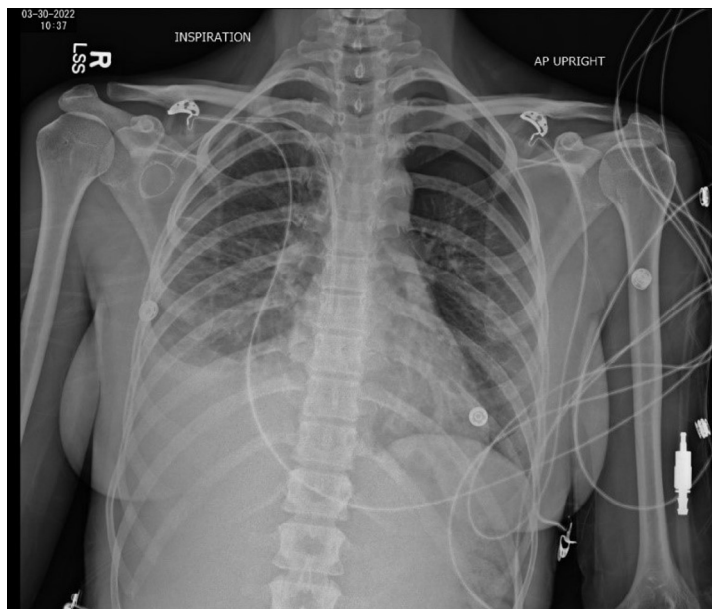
Chest x-ray with moderate left pneumothorax.
